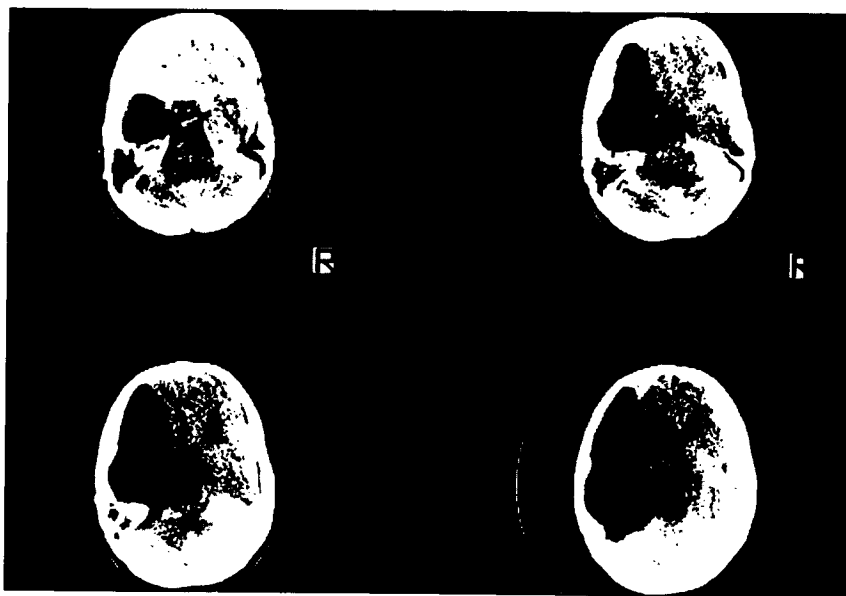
CT scans showing encroachment of arachnoid cyst on pituitary fossa and displacement of ventricular system to the right.
